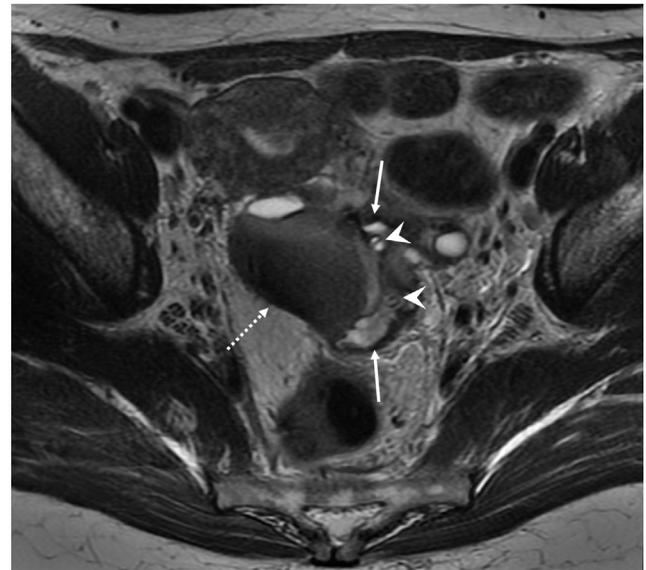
Axial T2-weighted MR image showing the newly collapse left endometrioma (solid arrows) with drainage catheter in situ (arrowheads). The right endometrioma is again seen (dashed arrow).
